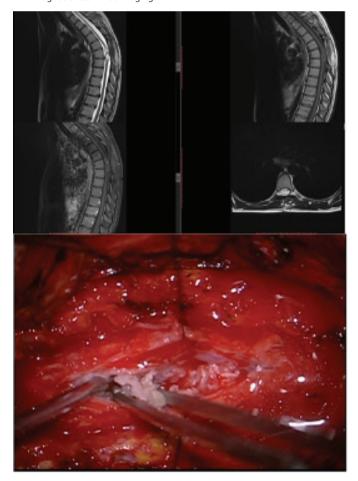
Preoperative T1 and T2- weighted MRI and intraoperative images of the second case
